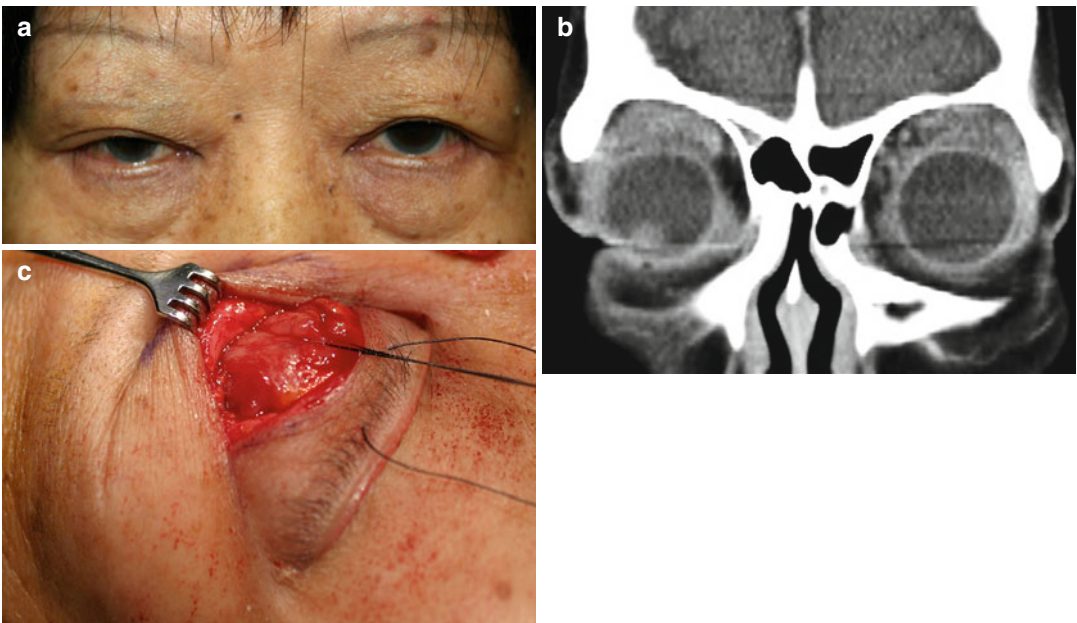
(a) Bilateral lacrimal gland enlargement from B-cell lymphoma in a patient referred for ptosis correction. (b) Bilateral lacrimal gland enlargement on CT scan. (c) Lacrimal gland biopsy
